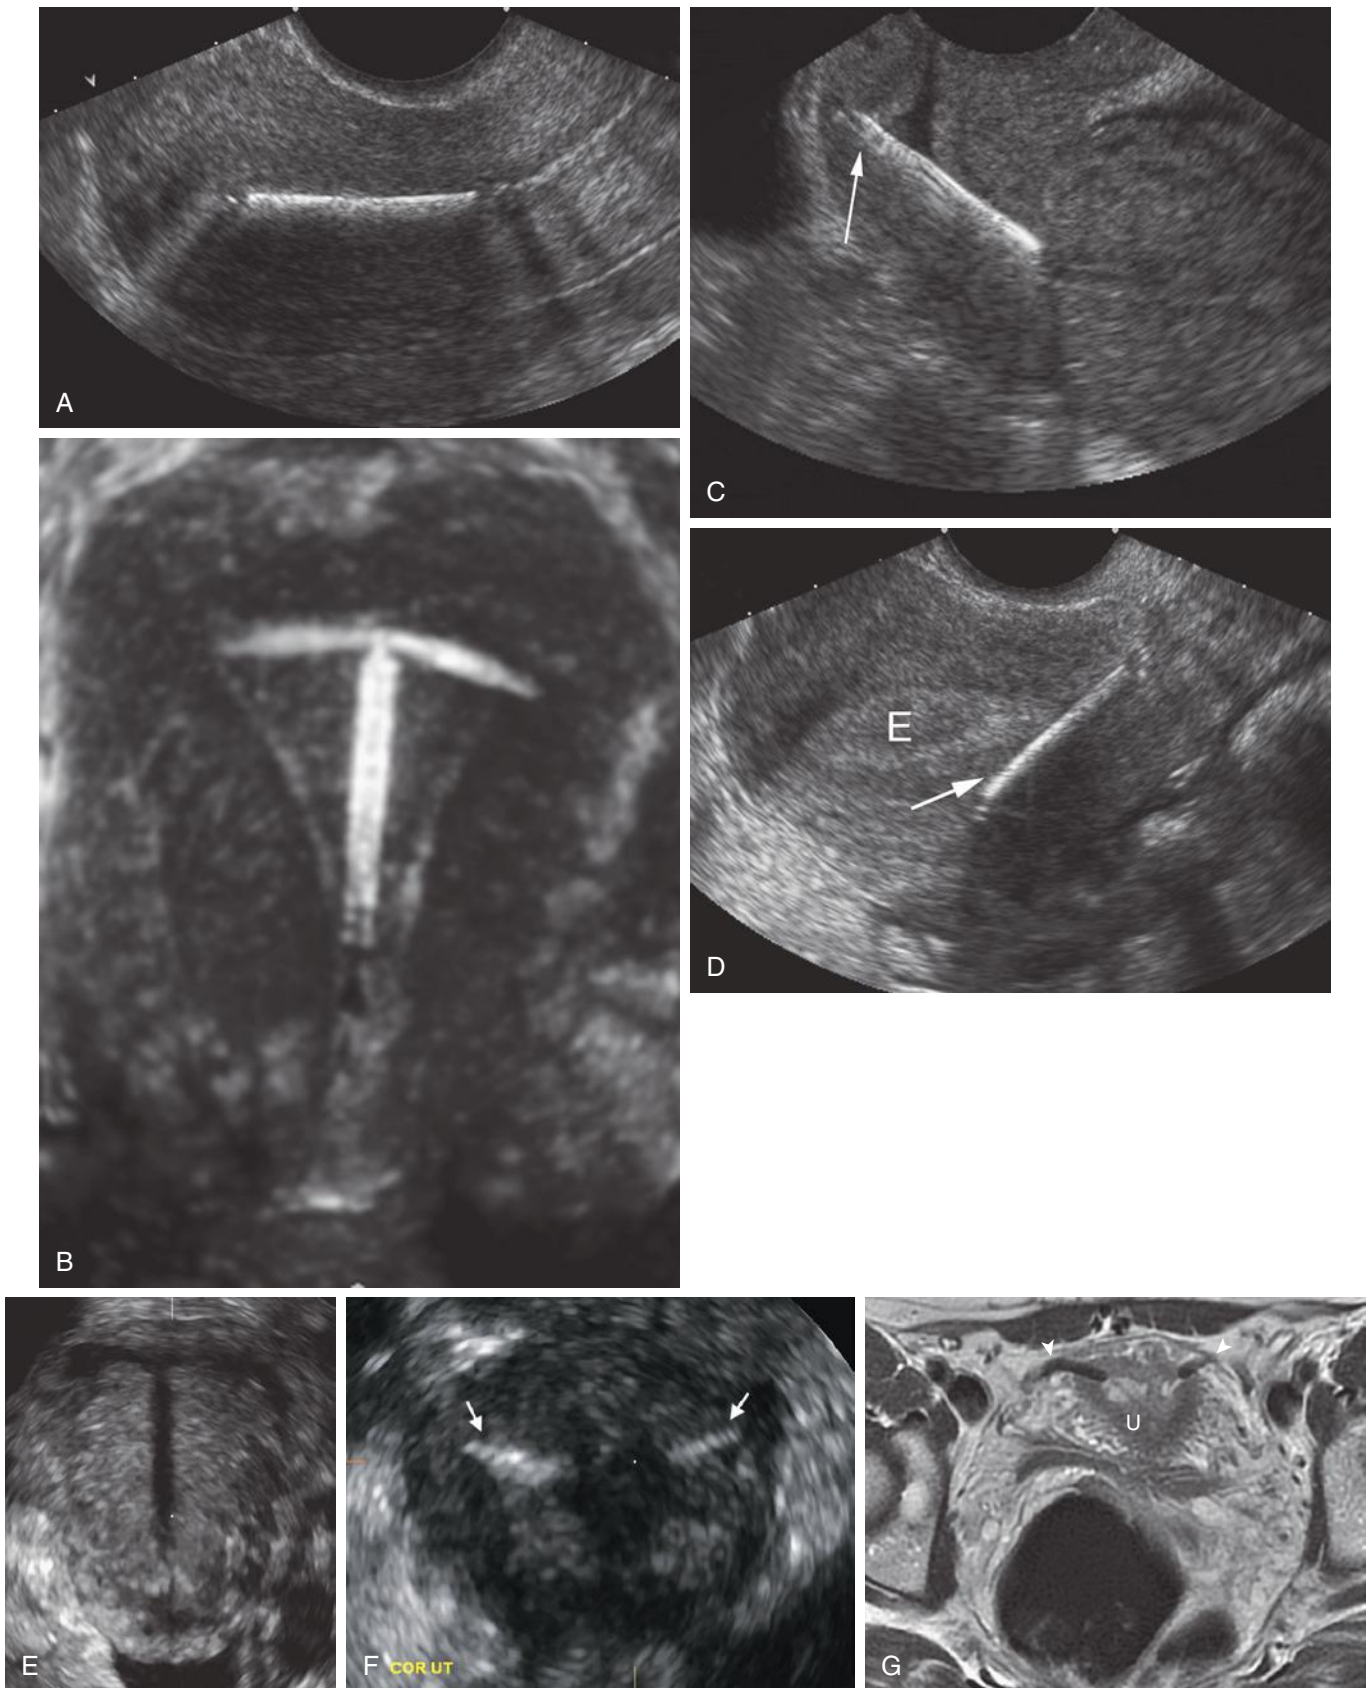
Intrauterine contraceptive devices. A, Transvaginal sagittal image demonstrating proper central position in the uterine fundus of an intrauterine device (IUD), which is linear and echogenic with dense posterior shadowing. B, Three-dimensional (3D) coronal sonogram demonstrating central positioning in the uterine fundus of an IUD. C, Transvaginal sonogram in a patient with a retroverted uterus demonstrating penetration of an IUD into the cervix (*arrow*). D, Transvaginal sonogram of an IUD extending into the posterior myometrium (*arrow*). E, endometrium. E, 3D coronal sonogram demonstrating reconstruction from the shadow (black contour rather than white as expected) of an IUD, which can lead to misinterpretation of the true location of the IUD. F, Linear, echogenic Essure devices (*arrows*) in proper position in both the right and left ostia of the fallopian tubes, seen on this 3D sonogram. G, Extension of the Essure devices (*arrowheads*) into the proximal portion of the fallopian tubes was confirmed on this T2-weighted MRI. U, uterus.
